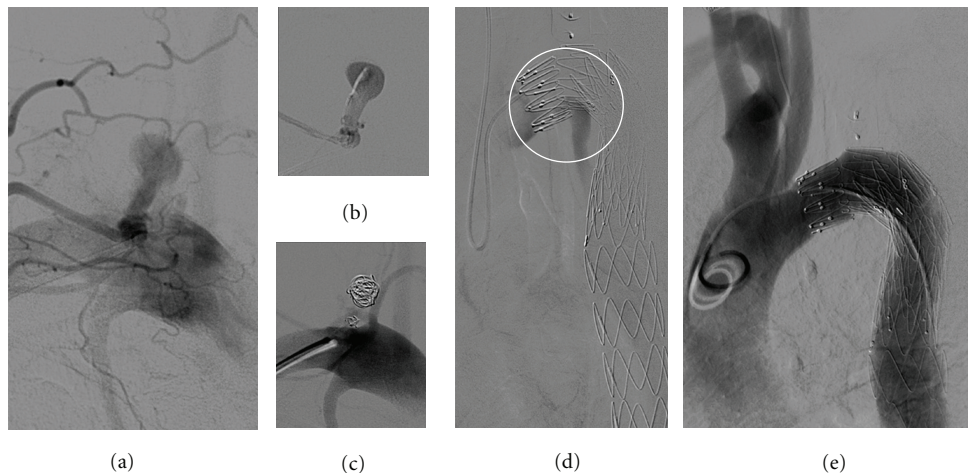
(a) Selective angiography of the left subclavian artery showing iatrogenic pseudoaneurysm after central line placement. (b) Selective intraaneurysmal angiography was performed with a 1.9 Fr microcatheter showing a long neck. (c) Result after embolization with microcoils demonstrating complete occlusion of the sack. (d) Selective angiography using a 5 Fr Sidewinder catheter shows a type I leak which can also be found on the angio-CT. (e) After angioplasty of the proximal endoprosthesis body the type I endoleak could be sealed completely.
